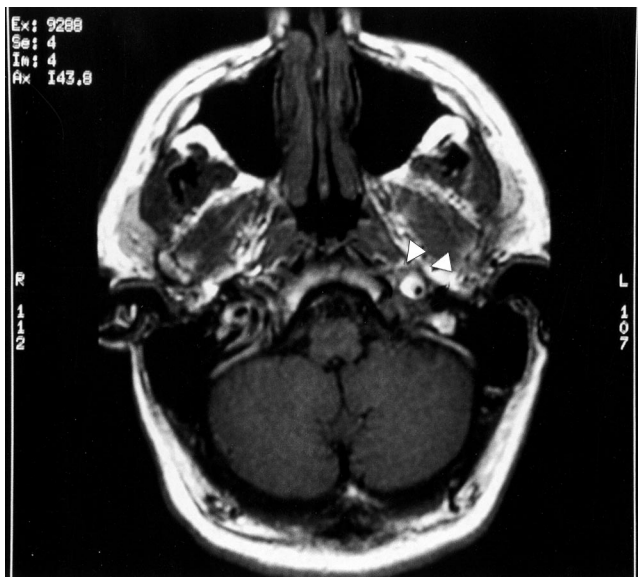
T1-weighted magnetic resonance imaging scan showing an abnormal flow pattern consistent with dissection of the left internal carotid artery (arrow).
